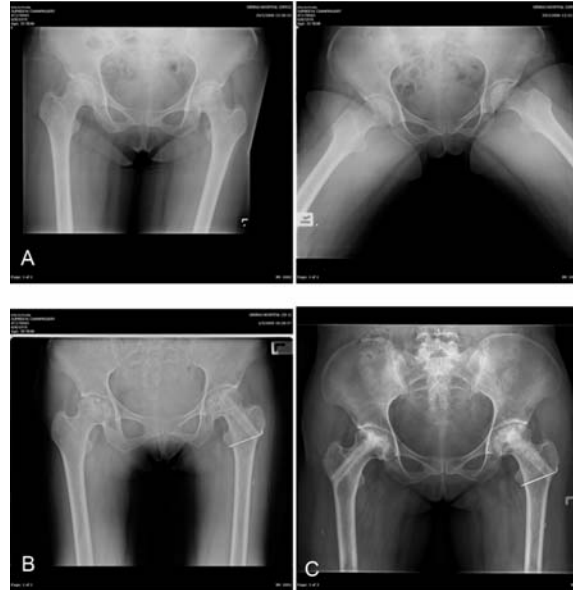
A 53 years old female with steroid uses for SLE treatment. She had total hip arthroplasty on the right side 3 years ago, developed new symptom on the other side. (A) Preoperative film show osteonecrosis stage II of left femoral head and right total hip arthroplasty. She underwent core decompression and concentrated autologous bone marrow injection. (B) After 4 years follow-up, the x-ray shows progression but no collapse of femoral head. The patient was pain free
